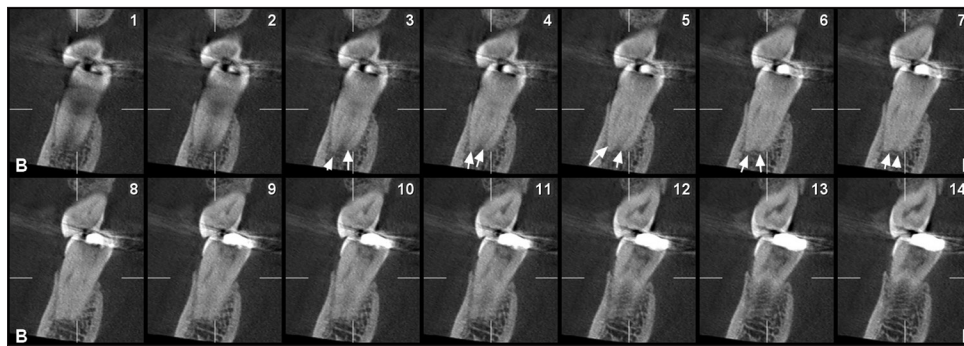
Cross-sectional cone-beam computed tomography sections of the mandibular first molar. Arrows denote the apical foramen of the mesial root
